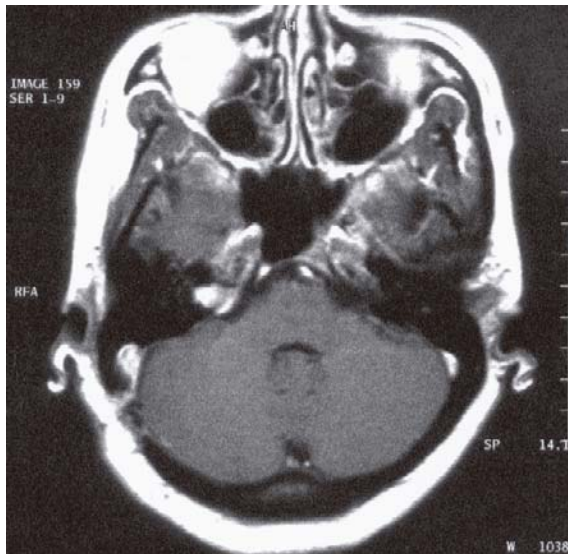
Repeat MR image taken six months post-surgery shows a small tumour remnant measuring 8mm in the right internal acoustic meatus.
